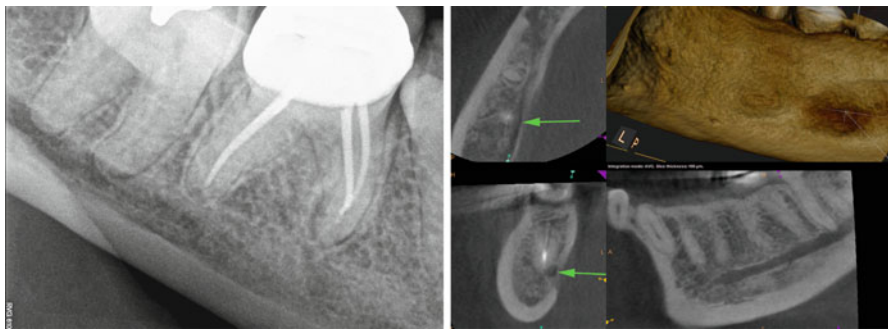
Left:* periradicular radiograph of an endodontically treated mandibular first molar tooth. *Right:* CBCT of the same mandibular first molar tooth; note the superimposition of the anatomical structures over the tooth anatomy; (*green arrows*)
